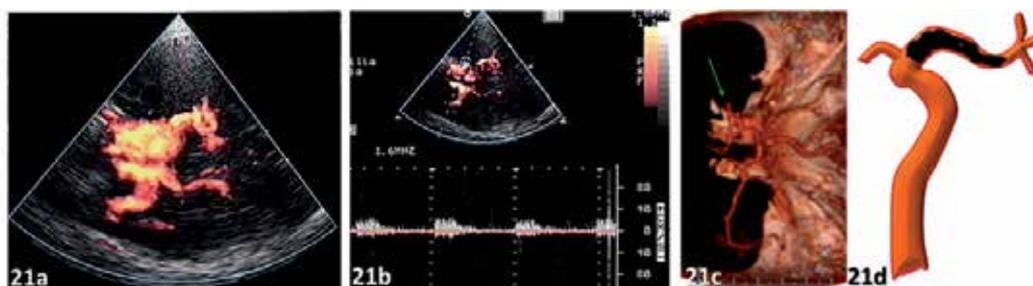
An example of MCA occlusion by TCCS, compared to CT angiography.
